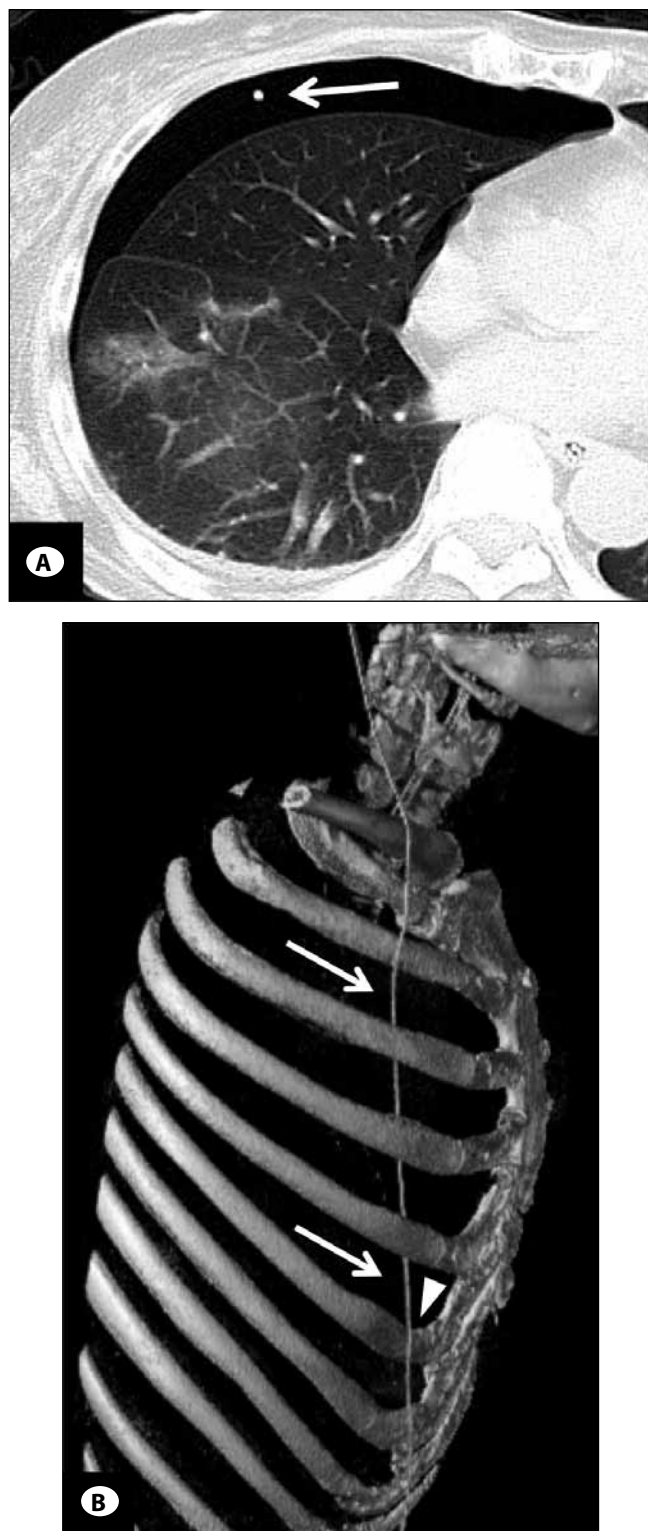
A) Thoracic computed tomography (CT) shows pneumothorax and a shunt tube passing through the thoracic space (arrow). B) Reconstructed three-dimensional CT shows the shunt tube passing underneath the 3rd to 5th ribs (arrows). CT also shows an indentation at the 6th rib at the tract of the shunt tube (arrow head), which might make the shunt passer likely to migrate underneath the 5th rib.
